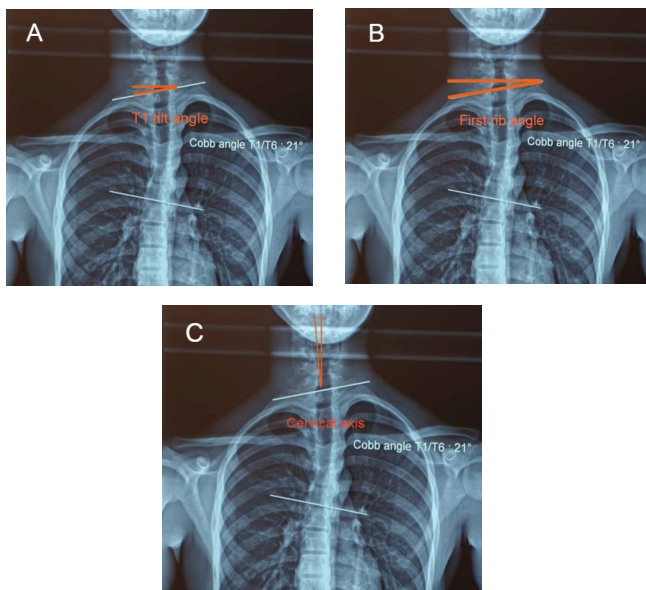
Medial shoulder imbalance and neck tilt radiographic parameters. A, T1 tilt angle. B, First rib angle. C, Cervical axis.
